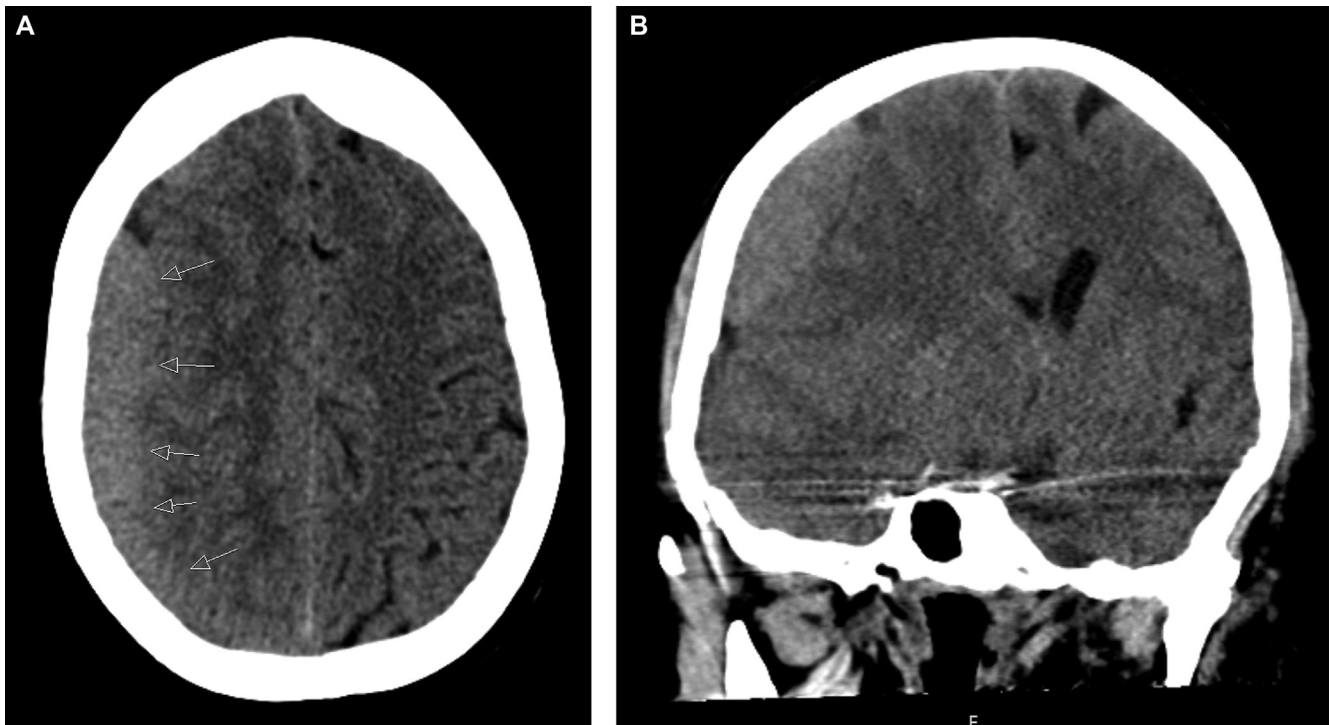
(A) Pre-operative axial, non-contrast CT (soft tissue window) demonstrates a right-sided fronto-parietal, slightly hyperdense subdural collection of plasma cell myeloma, initially thought to be an acute subdural hematoma. (B) Coronal view showing the same subdural lesion with secondary mass effect. A midline shift is also seen.
